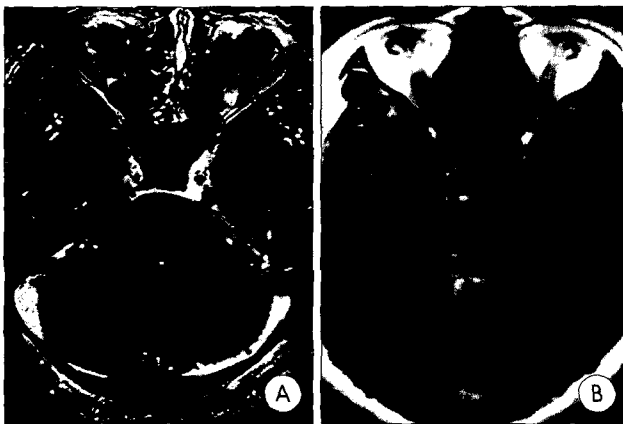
Case 21. A 34-year-old woman developed headache and left side paresthesia. Axial magnetic resonance (MR) image (A) shows a cavernous hemangioma in the right side of upper pons. She underwent gamma knife radiosurgery. At 5 months after radiosurgery, she experiences aggravation of neurologic symptoms. Axial T1-weighted MR image (B) shows an increase in the size of the lesion suggesting rebleeding or swelling possibly related with radiation effect.
